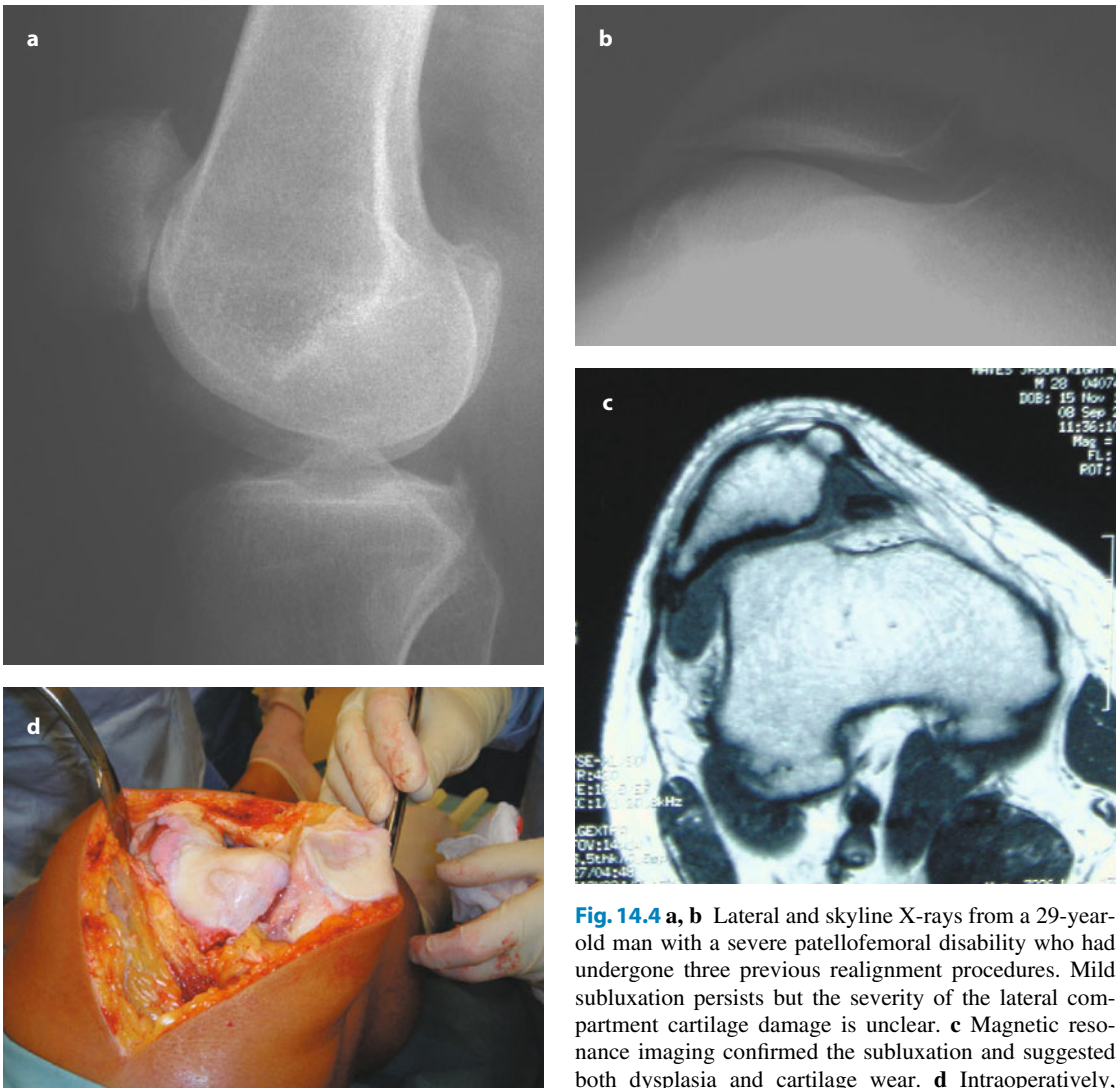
a, b Lateral and skyline X-rays from a 29-year-old man with a severe patellofemoral disability who had undergone three previous realignment procedures. Mild subluxation persists but the severity of the lateral compartment cartilage damage is unclear. c Magnetic resonance imaging confirmed the subluxation and suggested both dysplasia and cartilage wear. d Intraoperatively, gross cartilage loss and wearing extending around onto the lateral aspect of the lateral femoral condyle were seen. Note also the mild trochlear bump and dysplasia. Note also that a lateral approach has been used to aid correction of the maltracking. Despite his extremely young age, he did well with a patellofemoral replacement
